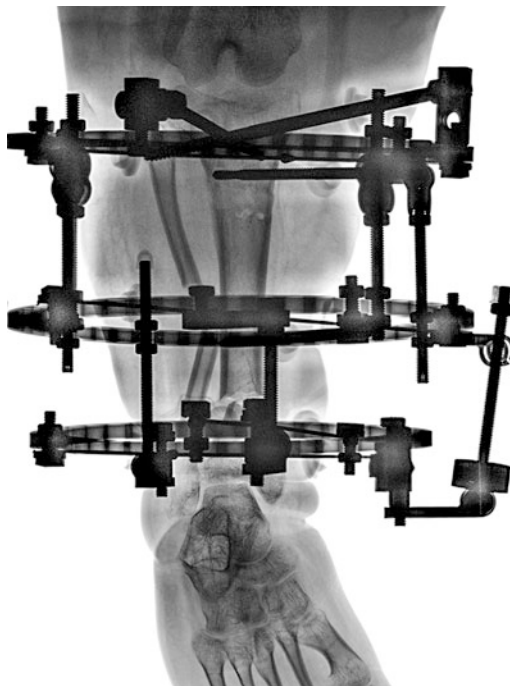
AP radiograph of the tibia after completion of the distal tibial varus deformity correction. At this time, the bone segments of the right tibia were stabilized, and analogous treatment was initiated for similar deformity correction of the left leg
